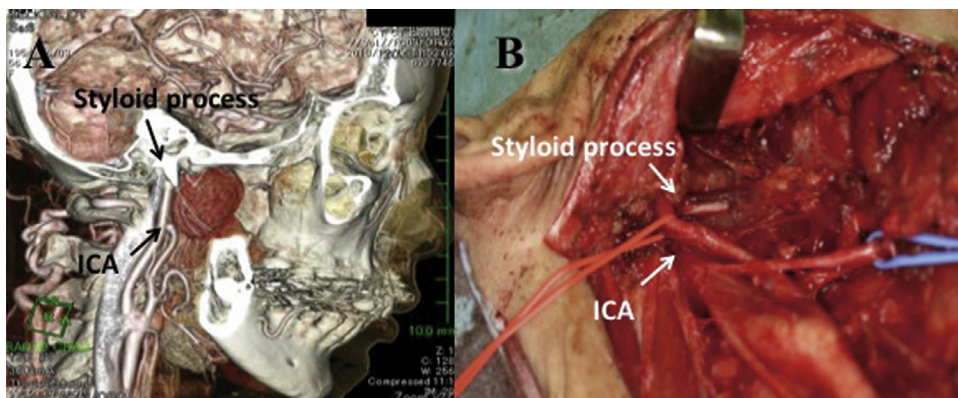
(A) Three-dimensional computed tomography images. (B) Intraoperative photo of the mandibular preserving oropharyngectomy. ICA: internal carotid artery.
